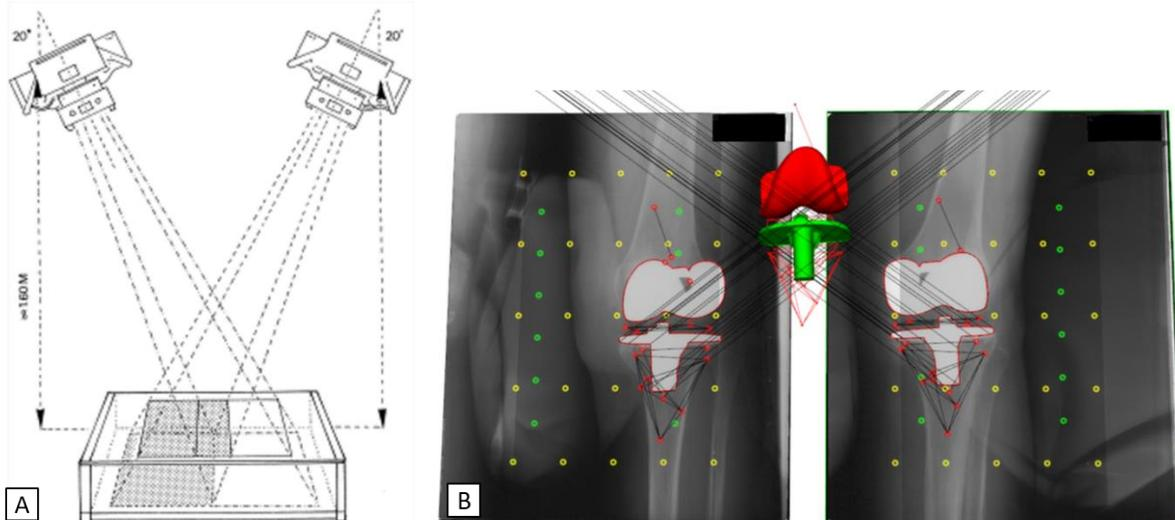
A) The RSA set-up consists of two separate roentgen tubes with corresponding digital radiography detectors and one calibration cage. The imaging body part is positioned on top of the calibration cage at the joint of interest of the X-ray bundles. Two separate roentgen images are taken virtually simultaneously. Image reproduced from [32]. B) Screenshot of the model-based RSA software.
